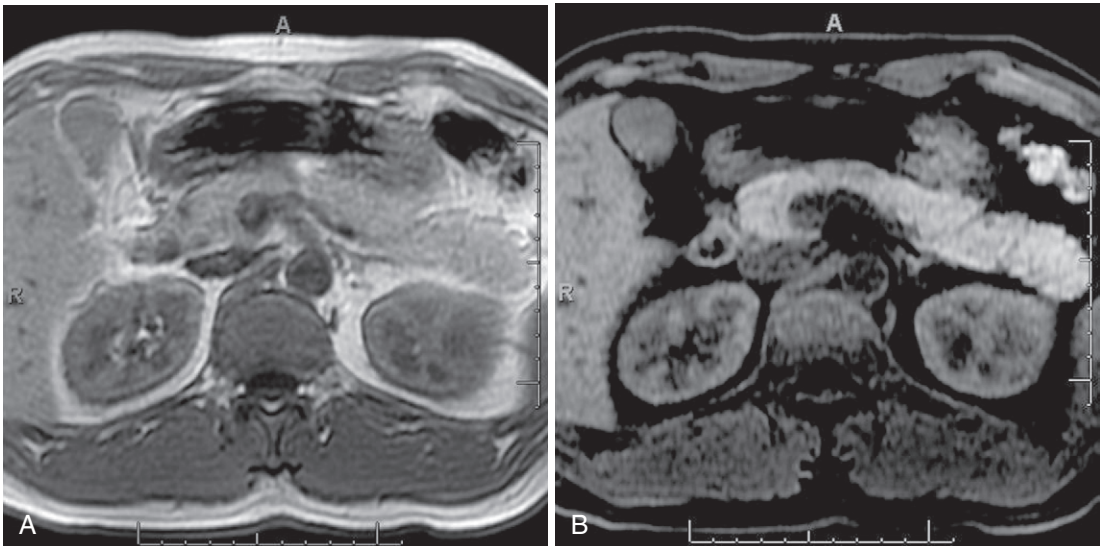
Normal appearance of the pancreas on T1-weighted images. A, In-phase T1-weighted image of the pancreas demonstrates the highest signal intensity of the abdominal organs secondary to aqueous proteins, paramagnetic substances, and endoplasmic reticulum. B, Relative increased signal intensity of the pancreas after fat suppression due to increased dynamic range.
